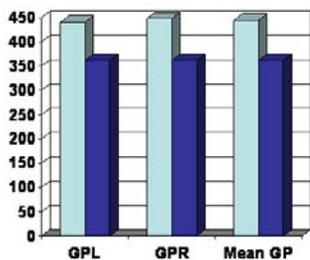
GP signal intensities calculated from T₁-weighted MRI.
